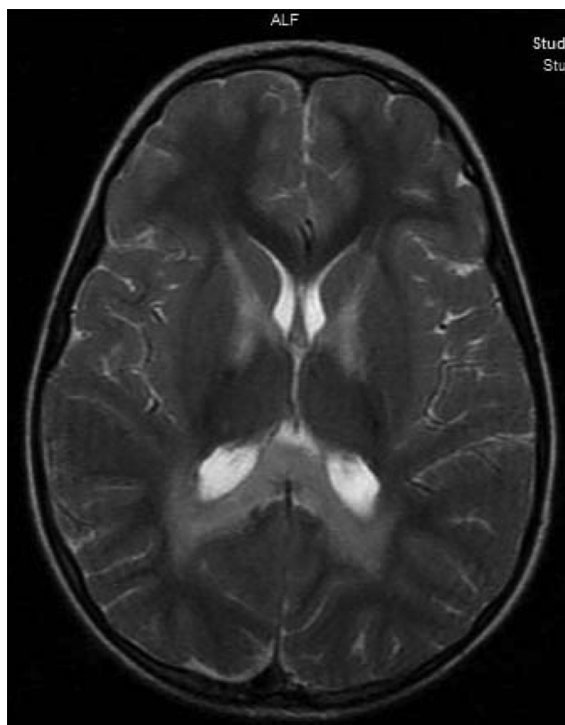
T2-weighted magnetic resonance image (MRI) shows bilateral symmetrical, high signal intensity on the white matter of both temporo-parieto-occipital lobes, including the internal capsules and splenium of the corpus callosum.
